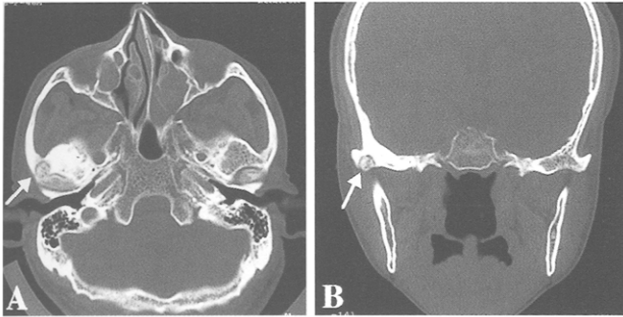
CT scans in axial (A) and coronal plane (B) showing lesion (arrow) in articular tubercle and osteosclerotic changes in surrounding bone.
